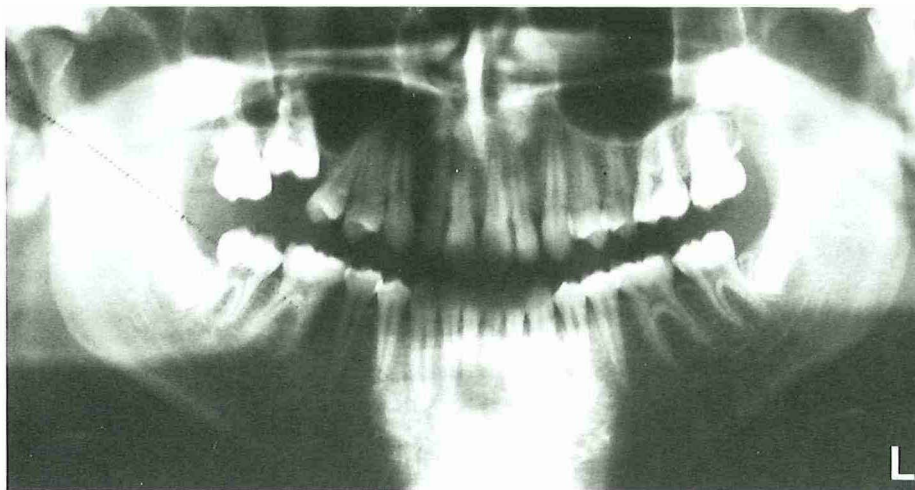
Orthopantomogram of a 16-year-old male showing secondary retention of the maxillary right first molar.
